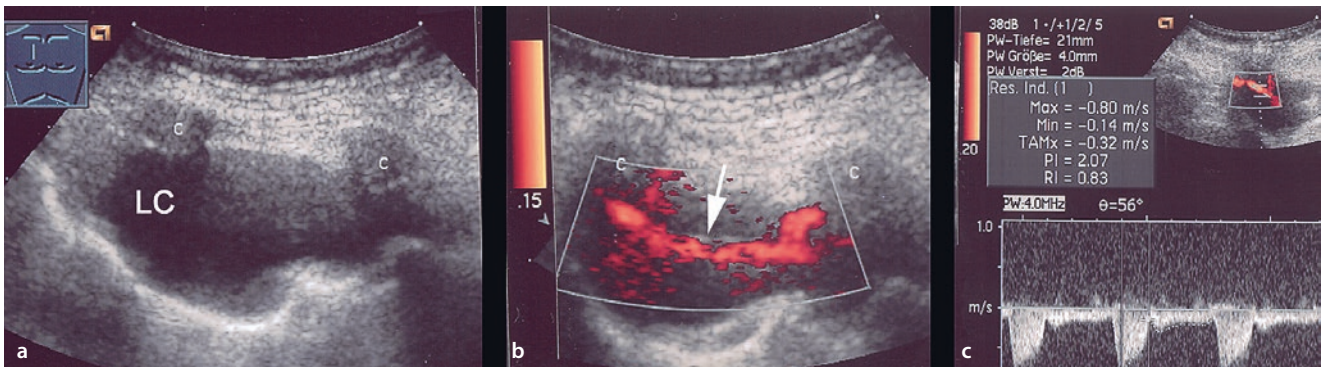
A 70-year-old man with a primary lung cyst. a On the B-mode image one finds an anechoic lesion close to the pleura. C ribs, LC lung cyst. b Color-Doppler sonography in the power mode shows a
